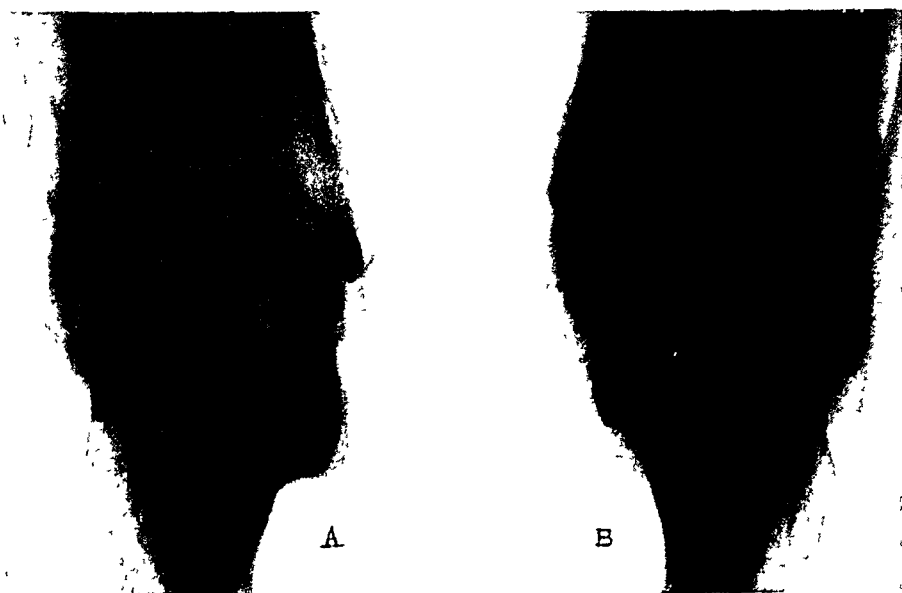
Radiograph obtained by the technic depicted in Figure 116D in a patient who had a talocalcaneal bridge on the left side (A). On the right side (B), which is normal, the joint between the sustentaculum tali and the neck of the talus can be seen.
